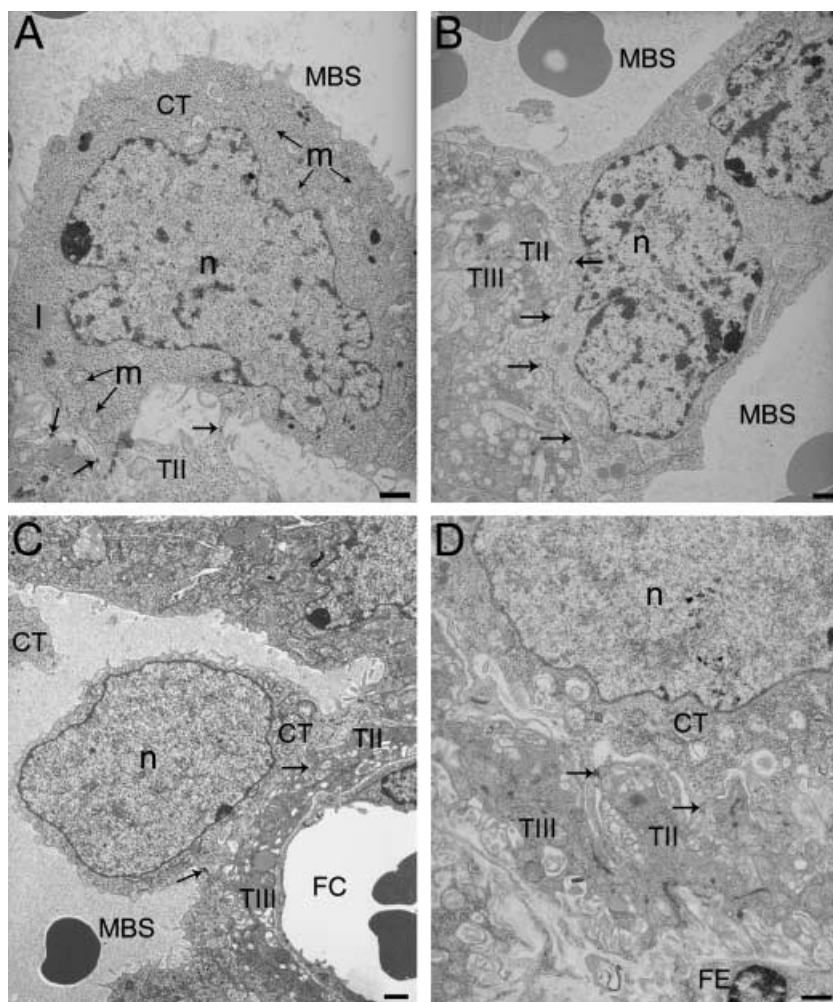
Development of the cytotrophoblast with gestational age. (A) E12.5 cytotrophoblast (CT) attached to the underlying syncytial layer (TII) by desmosomes (indicated by arrows). (B) E14.5 binucleate cytotrophoblast spanning a maternal blood space (MBS). (C) E16.5 cytotrophoblast. (D) E19.5 cytotrophoblast intimately attached to the syncytial layer beneath (TII). FC, fetal capillary; FE, fetal endothelium; I, lipid droplet; m, mitochondrion; n, nucleus; T III, syncytial trophoblast Layer III. Arrows indicate desmosome adhesion complexes between cytotrophoblast and cytotrophoblast or syncytial trophoblast Layer II. Scale bar = 1 µm.
